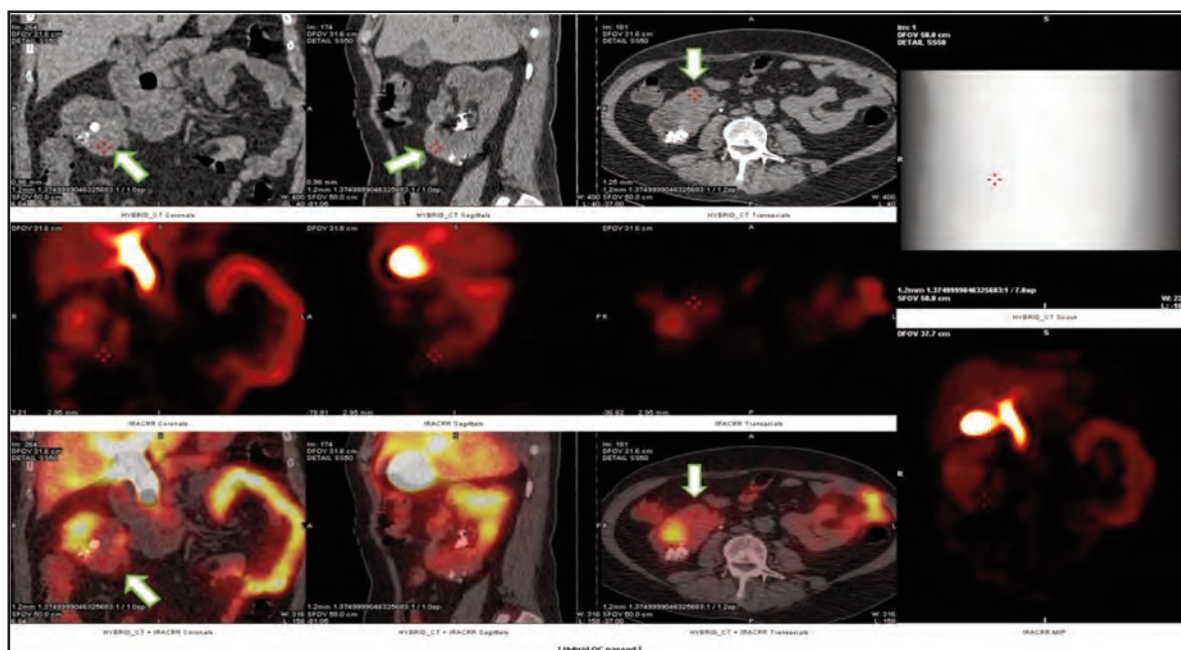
First row: CT images; second row: SPECT images; third row: SPECT/CT fusion images. Absence of sestamibi tracer uptake is observed at the right lower pole corresponding to a soft tissue lesion
